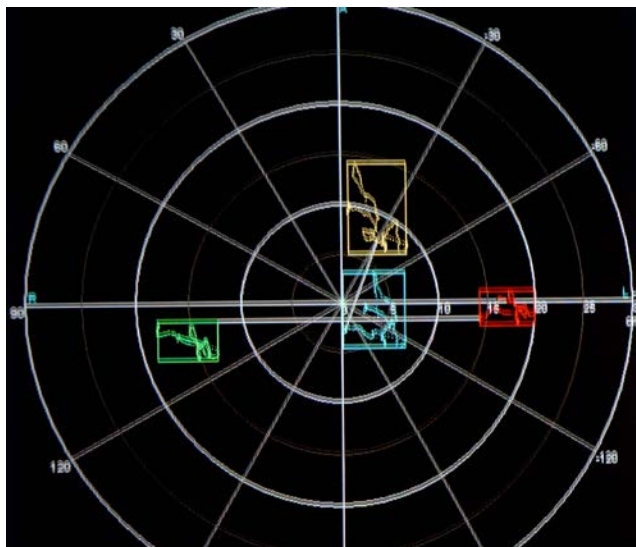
This ultrasound computer cranio-corpo-graphy (US-COMP-CCG) picture exhibits the results of a 1-minute standing test in a 66-year-old male. During the standing, he exhibits a longitudinal sway of 9.12 cm, a lateral sway of 6.17 cm, area coverage of the forehead marker of only 56.27 cm<sup>2</sup>. There is a torticollis angle of 20.24° to the left.
